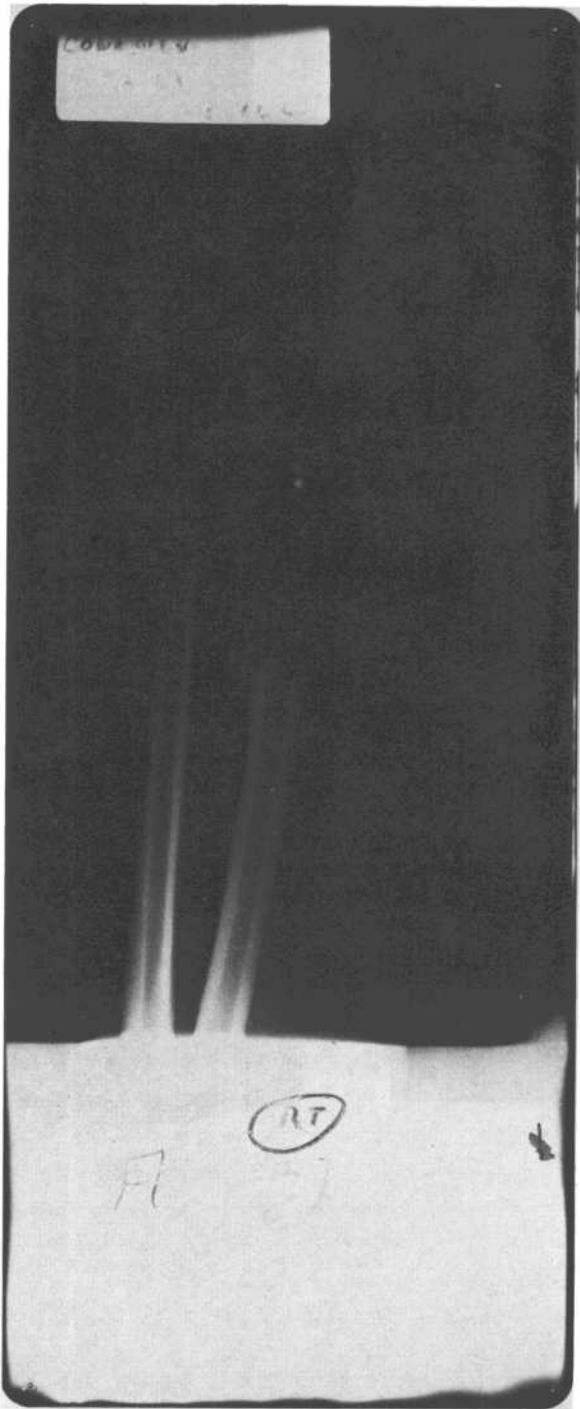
Photograph of an X-ray of the wrist, showing the extent of the fracture and missile fragmentation.
